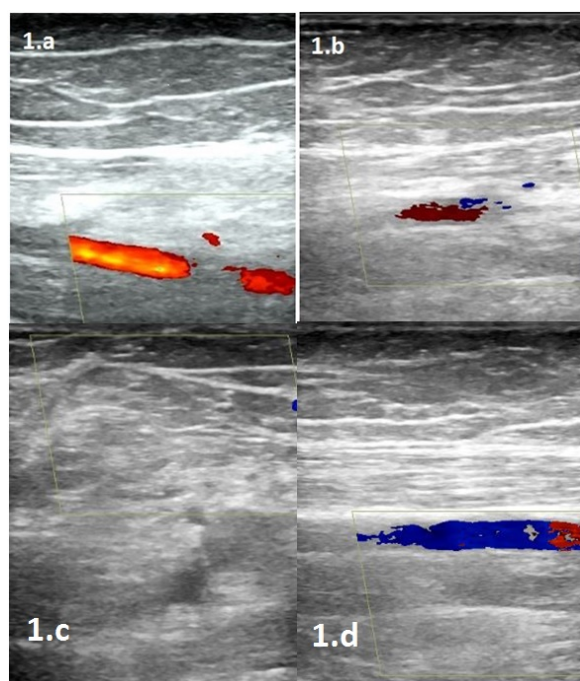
Pt.#126, 62 years old, female patient treated with total knee arthroplasty determined Deep Venous Thromboembolism in all deep venous sutructures in (a-d) Doppler USG of right leg while she was taking enoxaparin for thromboembolism prophylaxis at 22th day postoperatively.
